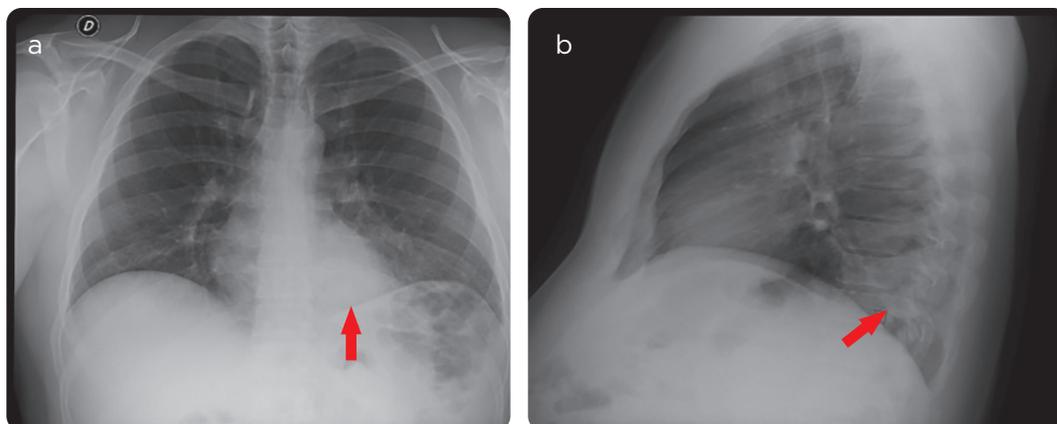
Chest X-ray PA and lateral, which shows alveolar opacity at the level of the lower left lobe (arrows).
